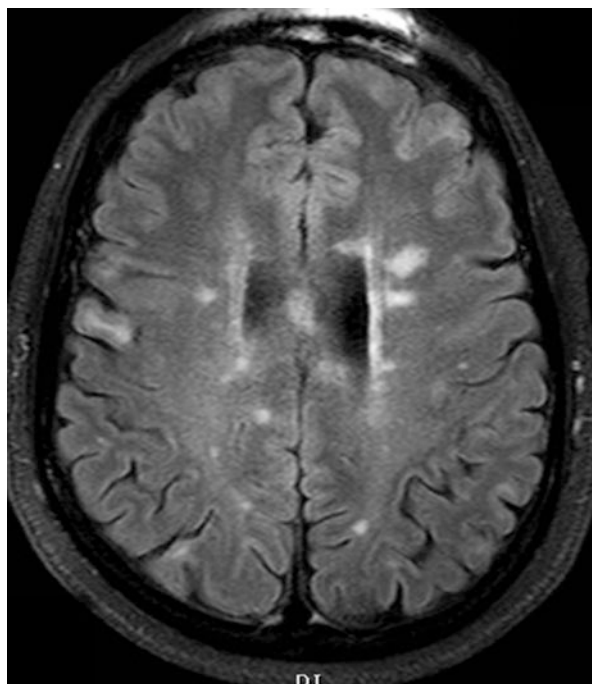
Multifocal T2 hyperintensity in periventricular and deep white matter of both cerebral hemispheres seen on MRI consistent with multiple sclerosis. *Photo courtesy of Fauzia Vandermeer, MD*
